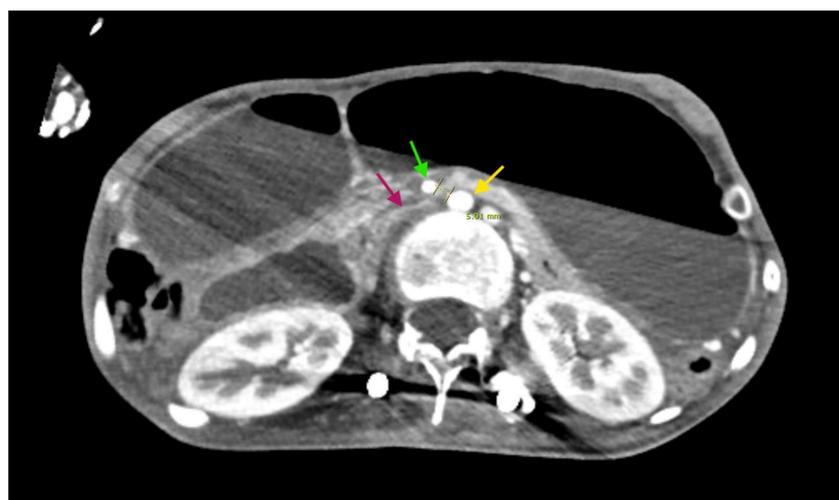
Axial contrast-enhanced abdominal CT scan demonstrating anatomical features of Superior Mesenteric Artery (SMA) syndrome.
